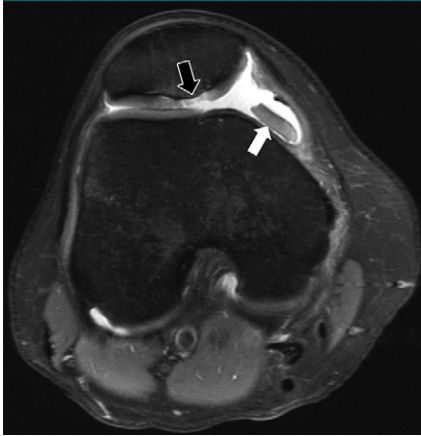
Axial intermediate-weighted fat-suppressed (2400/24) MR image of the knee shows an osteochondral injury (black arrow) at the median ridge of the patella with associated bone marrow edema. A shed fragment (white arrow) with linear low signal intensity at its edge represents a portion of the attached subchondral bone plate.
